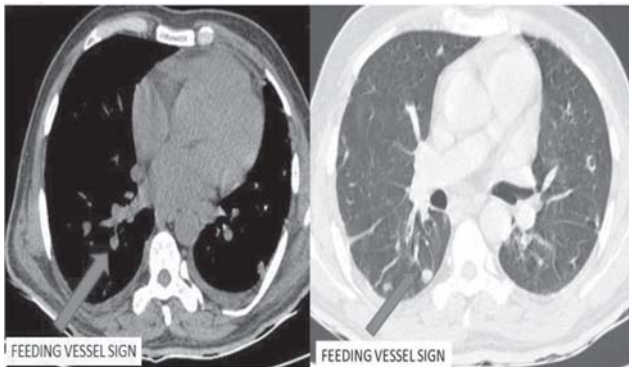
Computed tomographic of the thorax (mediastinal and lung window) transverse section below the level of carina showing the "feeding vessel sign" (arrow).
